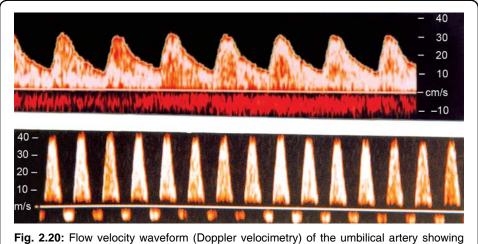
Flow velocity waveform (Doppler velocimetry) of the umbilical artery showing normal forward flow (above) and reversed end diastolic flow (below)
